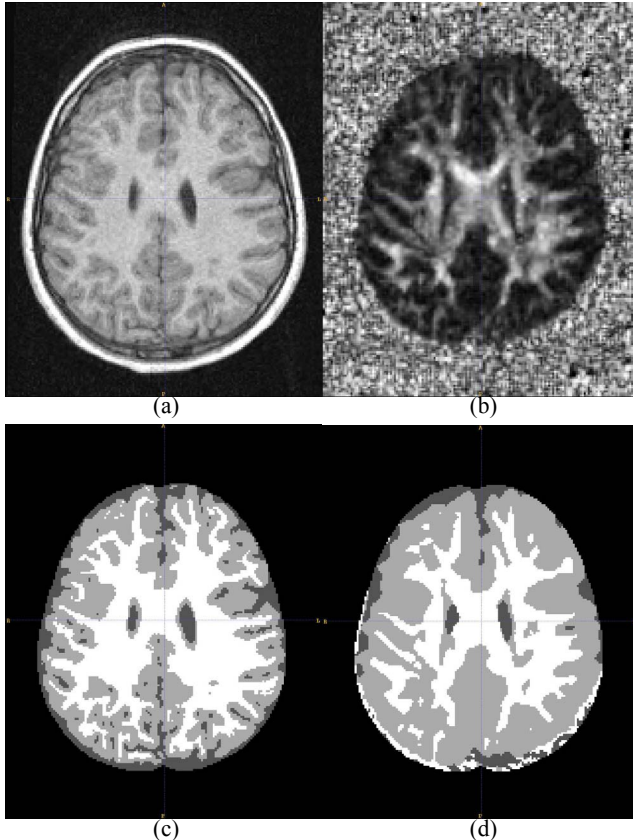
Axial slices showing *cortical* regions in the: (a) MR image, (b) FA image, (c) segmentation using the MR image alone, and (d) segmentation using the orthogonal tensor invariants alone.
